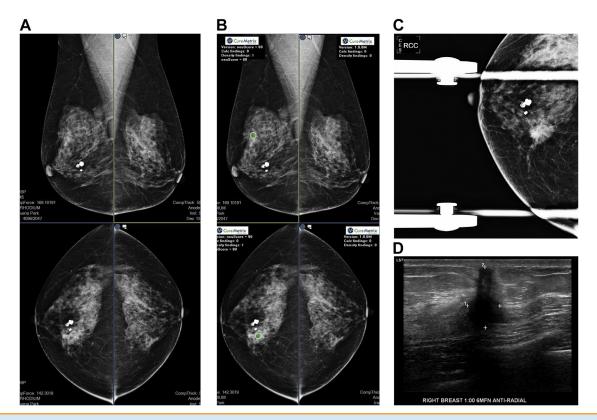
Biopsy-confirmed cancer triaged as suspicious. (a) Mediolateral oblique (MLO) and craniocaudal (CC) screening digital mammograms show heterogeneously dense breast parenchyma. On the right, a partially obscured asymmetric density was seen in the upper inner quadrant. (b) CureMetrix cmAssist artificial intelligence–based computer-aided detection software applied. The lesion is flagged in both projections and has a high neuScore (88 on the MLO image and 90 on the CC image). Note that there are no false flags. (c) Spot compression confirms a mass with architectural distortion. (D) Ultrasound shows a hypoechoic, shadowing, irregular mass confirmed to be an infiltrating ductal carcinoma.
